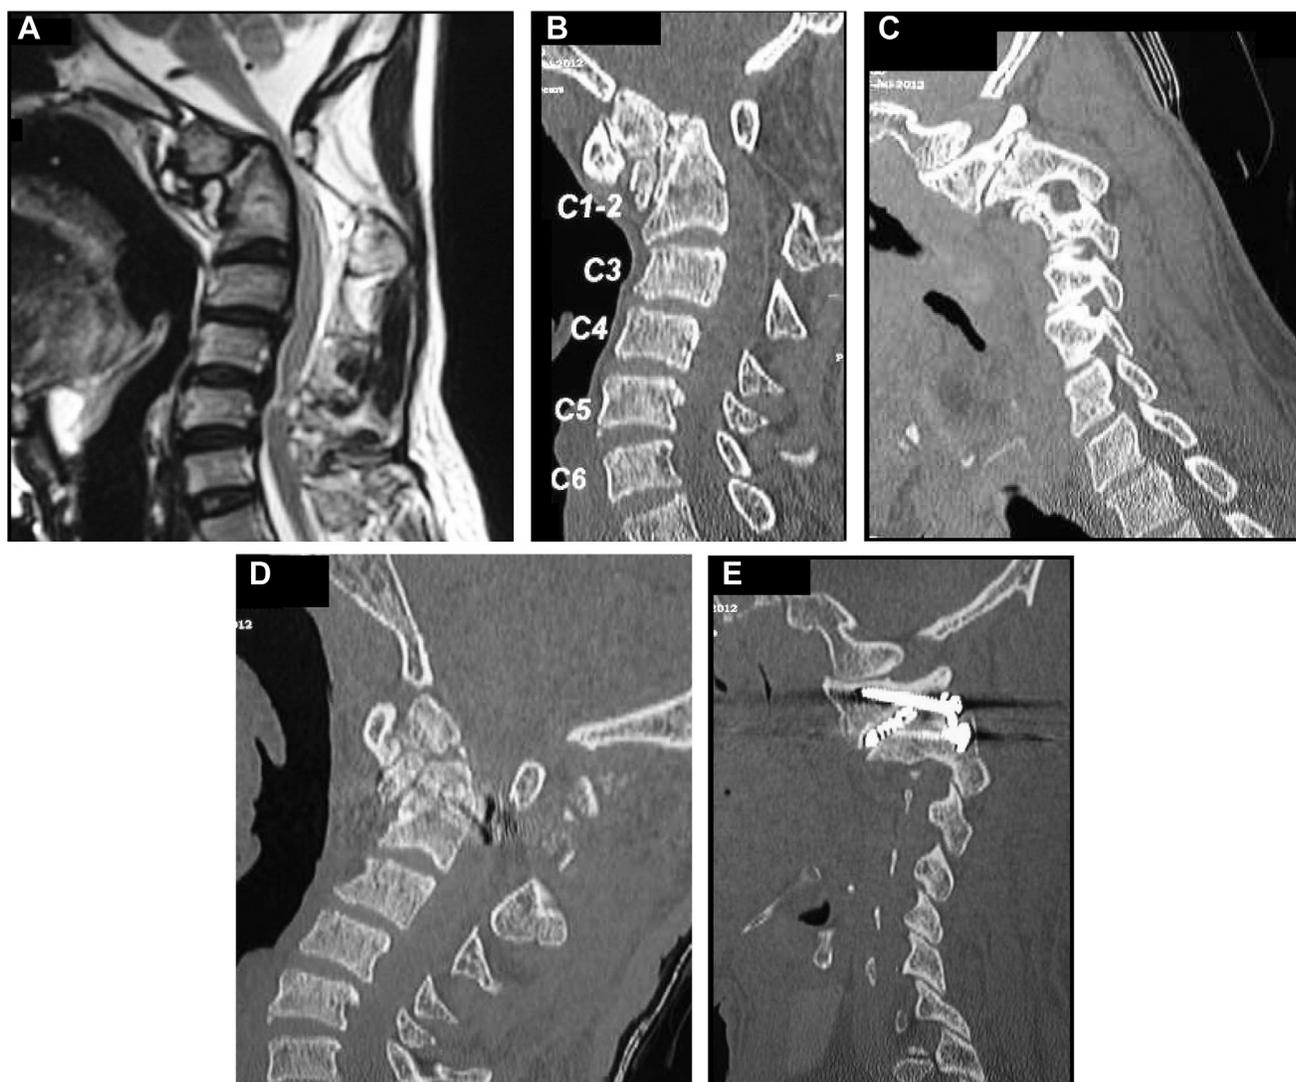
Images of a 47-year-old male patient with a “chronic” odontoid fracture. (A) T2-weighted magnetic resonance imaging showing the type I odontoid fracture. The displacement of the fracture segments has resulted in reduction in spinal canal dimension and cord compression. (B) Sagittal computed tomographic scan showing the fracture. Multiple small bone pieces
